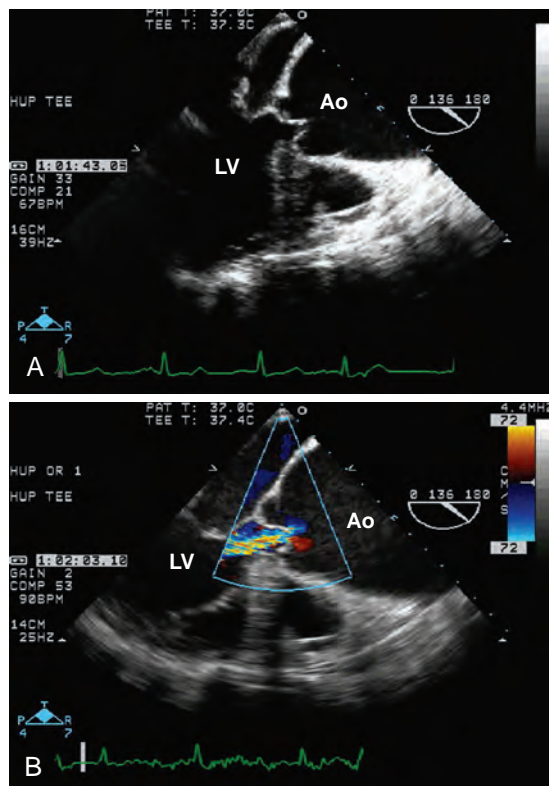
Transesophageal echocardiographic (TEE) mid-esophageal long-axis images of the aortic valve demonstrating aneurysmal dilation of the aortic root and ascending aorta (A). Doppler color-flow imaging (B) demonstrating severe aortic regurgitation caused by outward tethering of the aortic valve cusps by the aortic aneurysm. Ao, Aorta; LV, left ventricle.
